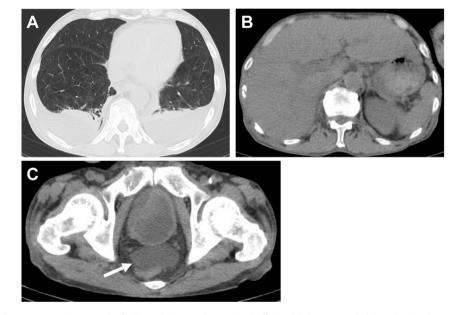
Computed tomography findings. The image shows pleural effusion (A), hepatomegaly (B), and ascites (C, arrow).
